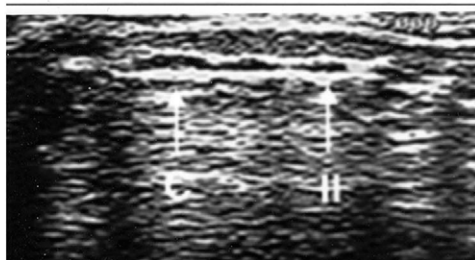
Left*, with a linear ultrasonography transducer (vascular probe), the trachea was presented by vertical medial section. *Right*, after a clear ultrasound verification of cricoid cartilage and tracheal rings, the site of puncture for percutaneous tracheostomy (usually between the second and third tracheal rings) or cricostomy can be determined.
